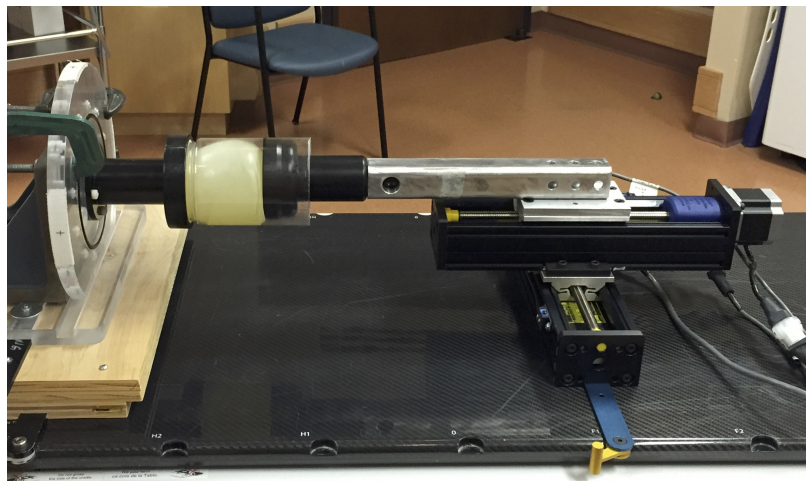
A deformable gel setup on the CT scanner bed as it is compressed by the acrylic piston connected to a stepper motor.
